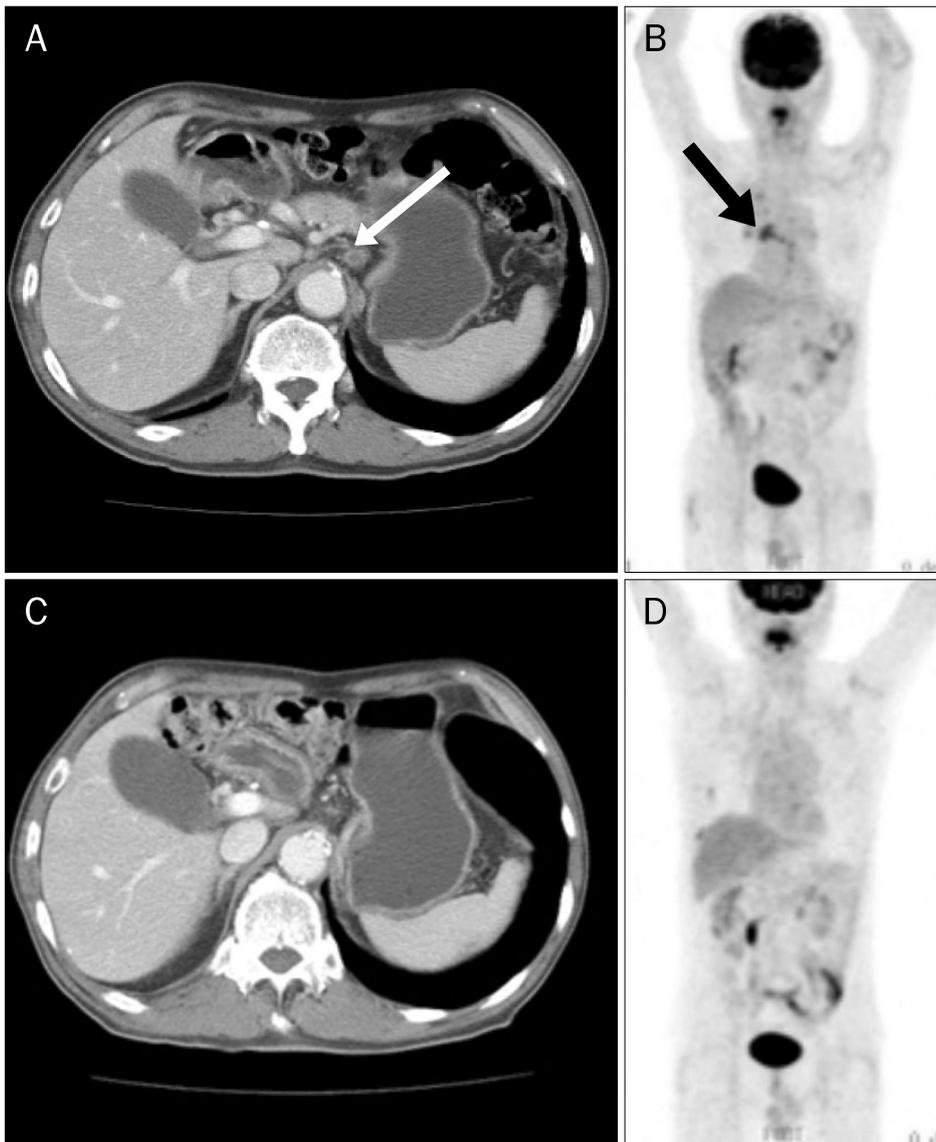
(A) Abdominal CT and PET CT image. Abdominal CT image suggested a single lymph node enlargement in the left perigastric area (arrow). (B) PET-CT image showed an increased flurodeoxyglucose (FDG) uptake in the lower esophagus (arrow) and no distant metastasis. The enlarged perigastric lymph node completely disappeared on abdominal CT (C) and the FDG uptake in the esophagus was not detected on the PET-CT scan after ten cycles of chemotherapy (D).
